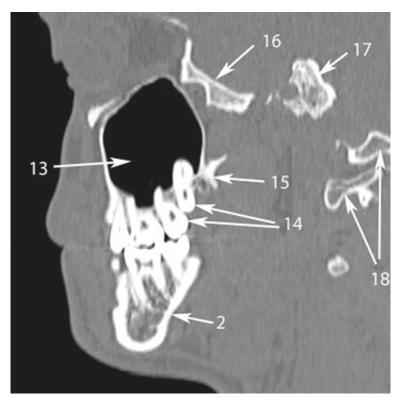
Sagittal CT scan at the level of maxillary molars. *Numbers* with *arrows* denote the following anatomical structures: 2 – mandible; 13 – maxillary sinus; 14 – upper molars; 15 – pterygoid process; 16 – sphenoid bone; 17 – occipital bone; 18 – cervical vertebrae.
